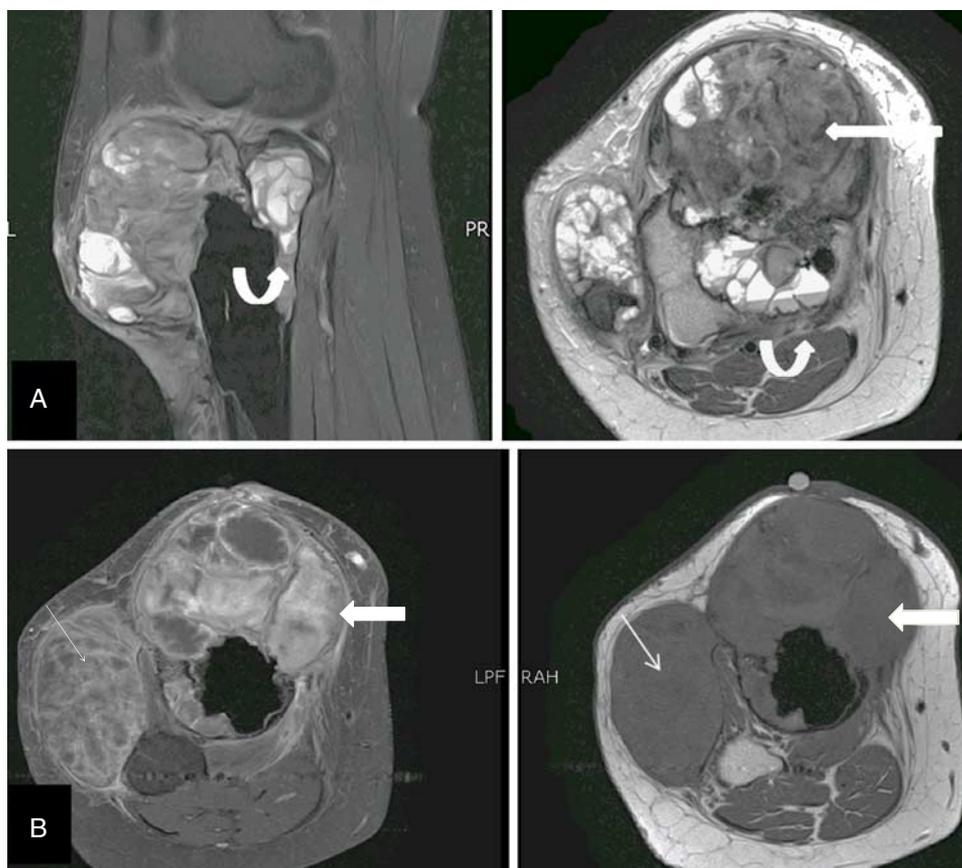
Magnetic resonance images from a 27-year-old female with an aneurysmal bone cyst of the proximal tibia. A, Sagittal STIR and axial T2WI image show multicystic expansile lesion showing multiple fluid/fluid levels in the proximal condyle of right tibia extending up to the articular surface. Signal intensities of the various components of lesion. Solid component is hypointense to marrow (long arrow). Superior cyst layer is isointense and dependent portion of the cyst is slightly hyperintense (curved arrow). B, Axial T1WI without contrast and T1W C + magnetic resonance imaging reveal avid enhancement of the septa (thin arrow) and soft tissue (thick arrow) between the dilated, blood-filled cystic spaces.
